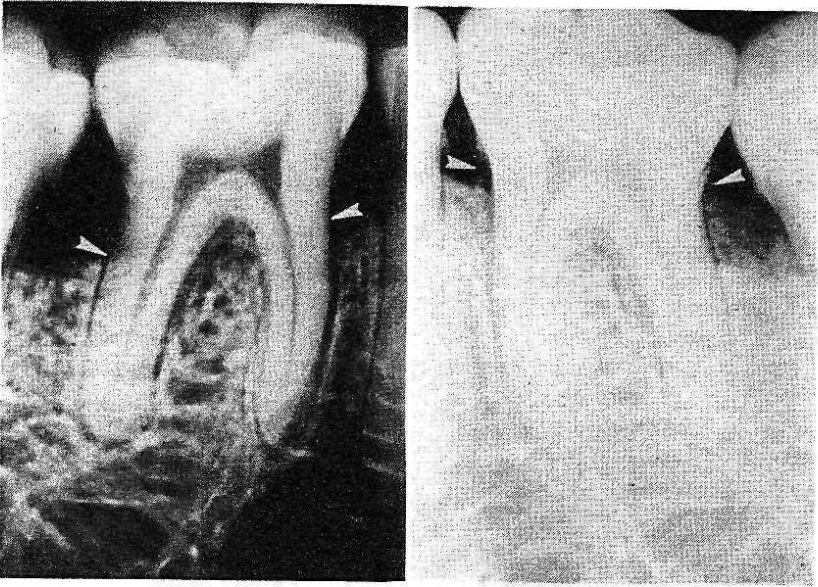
Influence of exposure time as radiographic image. Too high exposure time results in a too dense image with high contrast resulting in "burn out" of the interproximal alveolar crest. (A. G. Richards, University of Michigan, Ann Arbor, USA).
